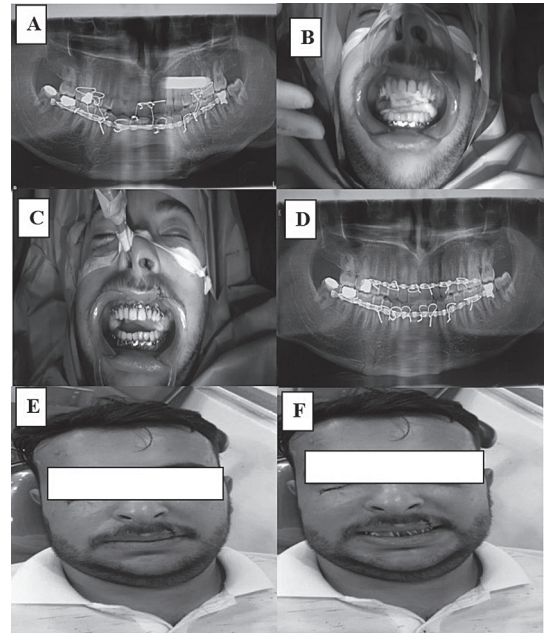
A- Preoperative OPG radiograph, B- Preoperative view, C- Upper & lower arch bars were placed, D-Postoperative OPG radiograph, E& F- postoperative views
